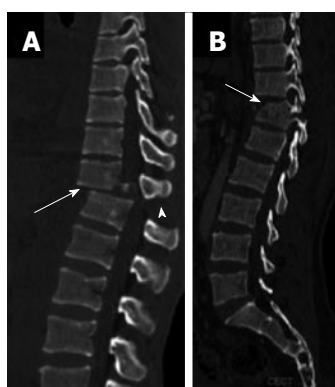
Type B1 flexion distraction injury. Sagittal computed tomography images show disruption through the posterior ligamentous complex (arrowhead) with either anterior disruption through the disc (arrow) constituting B1.1 injury (A) or a type A fracture anteriorly (arrow) constituting type B1.2 injury (B).
